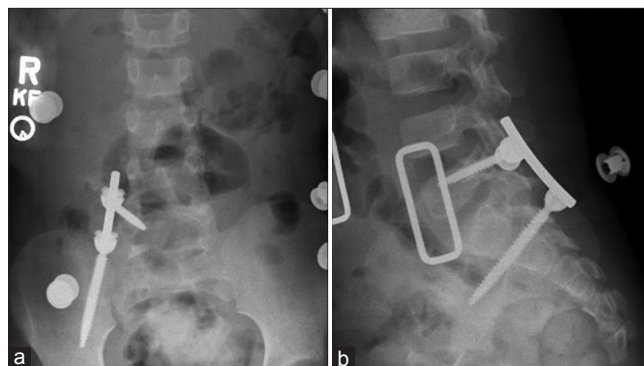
Upright lumbar spine X-ray with LSO brace in place showing final instrumentation placement. (a) Anterior-posterior X-ray. (b) Lateral X-ray.
